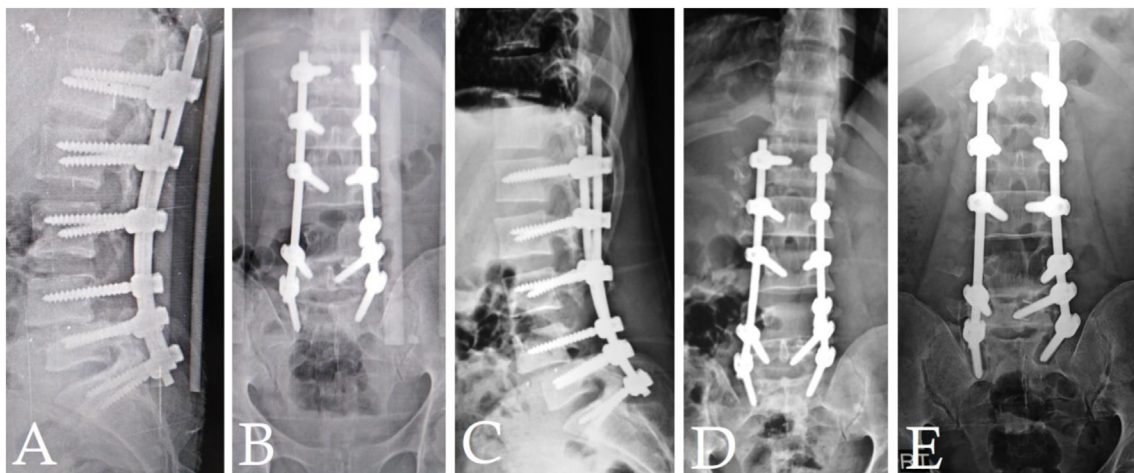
Postoperative X-rays images (A,B) lateral and AP views at 6 weeks follow-up showing adequate reduction and construct, (B,C) lateral and AP views at 6 months follow-up showing stable construct, (E) AP view at 9 months follow-up showing stable construct with evidence of mobile segment in the form of halos around lower screw construct.
